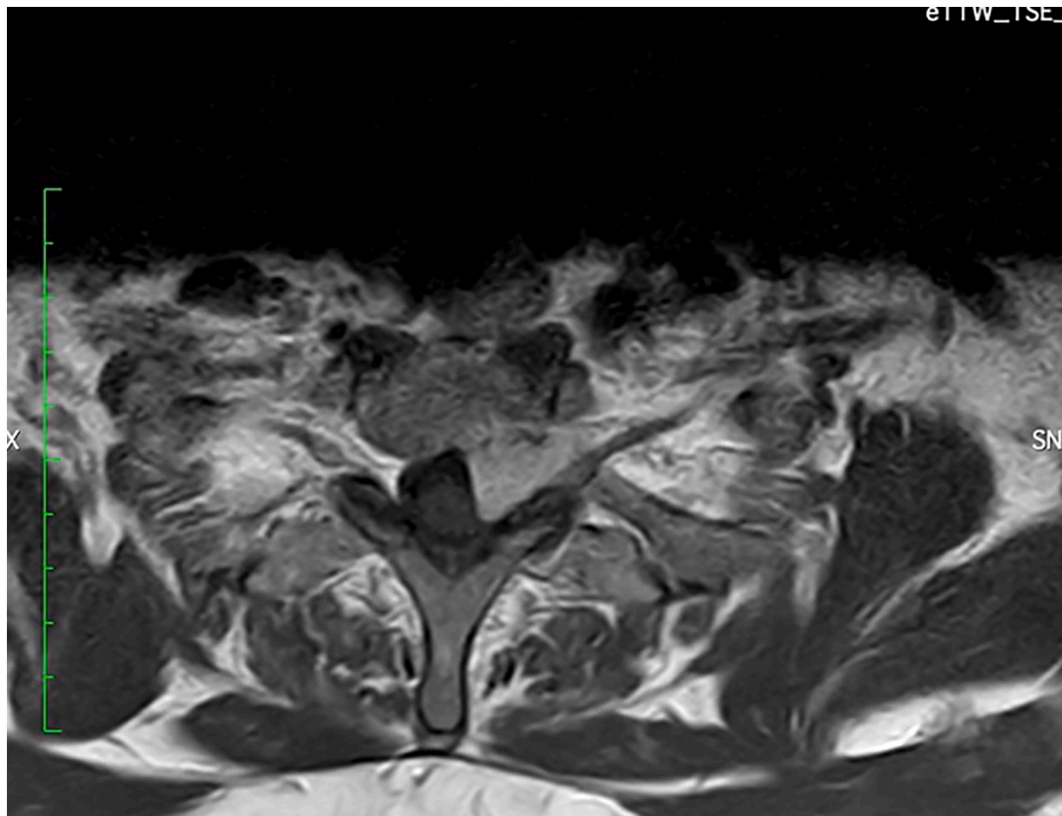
in this MRI slice, it is possible to glean that the C8 root is posteriorly dislocated by the tumor in the foramen, rather than being the origin of the lesion.
